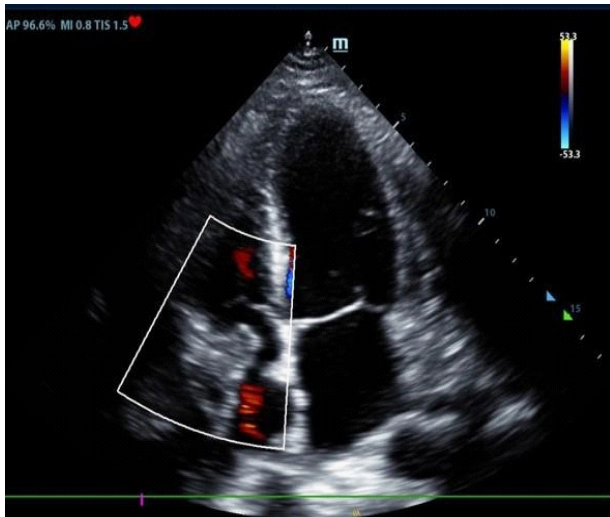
Transthoracic Doppler echocardiogram, apical window, four-chamber view, showing a vegetation on the right atrial free wall.
